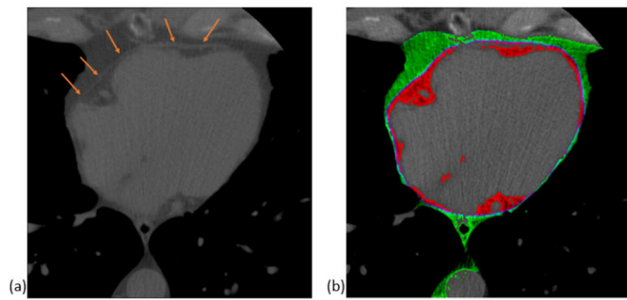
The pericardium is presented in (a) indicated by orange arrows, the pixels with red color in (b) are the epicardial fat in the cardiac CT scans.
